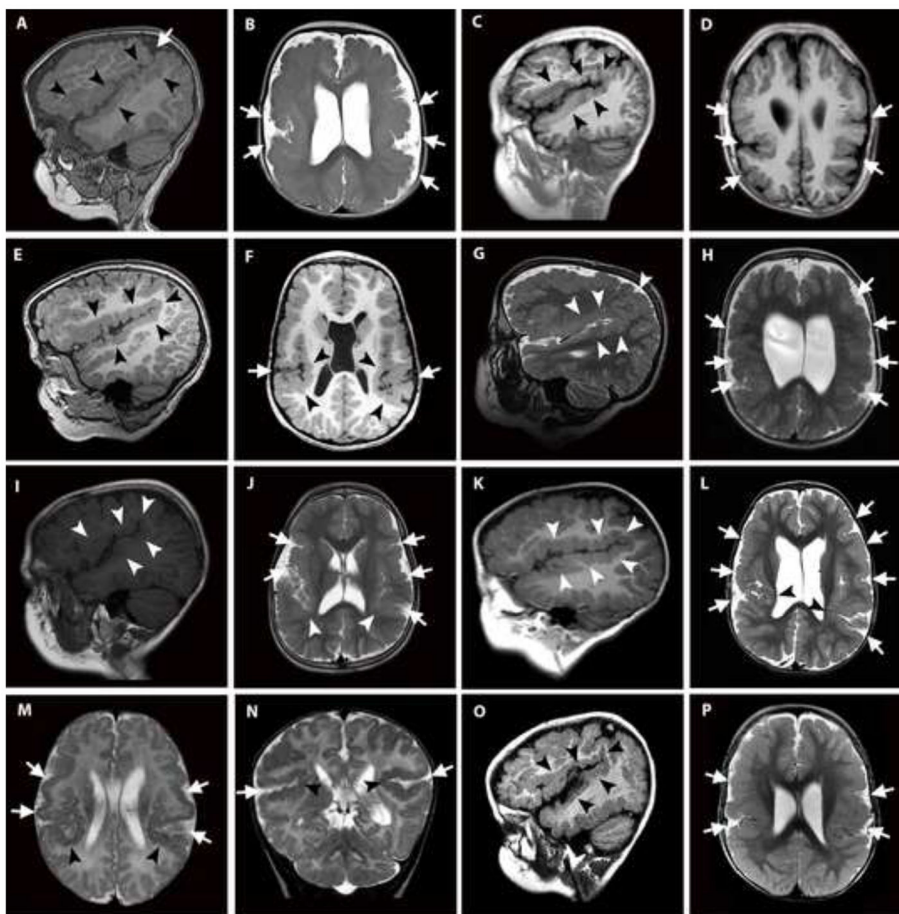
Brain MRI images of patients with constitutional *PIK3R2* mutations
